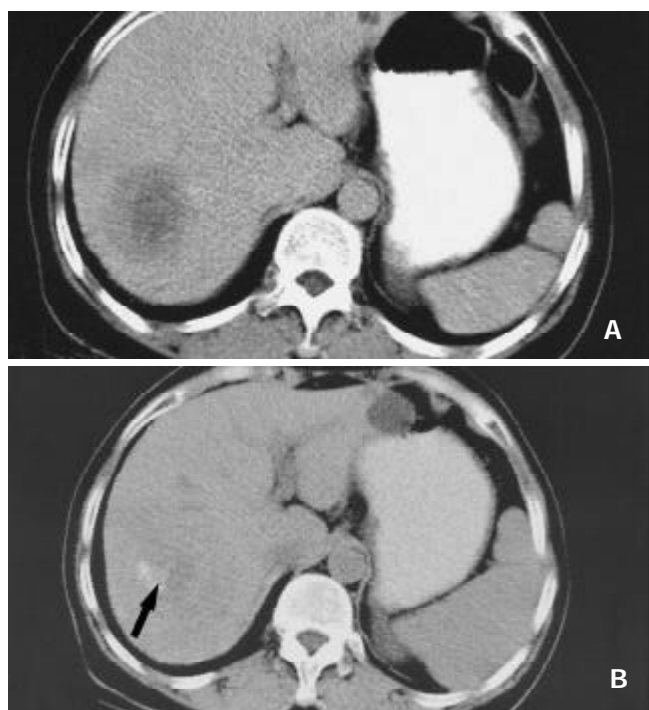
Nearly complete necrosis in a large HCC located in segment 7 and treated with RF therapy in a 57-year-old colorectal cancer liver metastases. (A) CT scan obtained prior to therapy demonstrates a large, 5.3 cm nodules. (B) CT scan obtained 6 months after RF therapy shows nearly complete tumor necrosis. A small hypervascularized area of viable neoplastic tissue (arrow) remains at the posteromedial aspect of the tumor.
